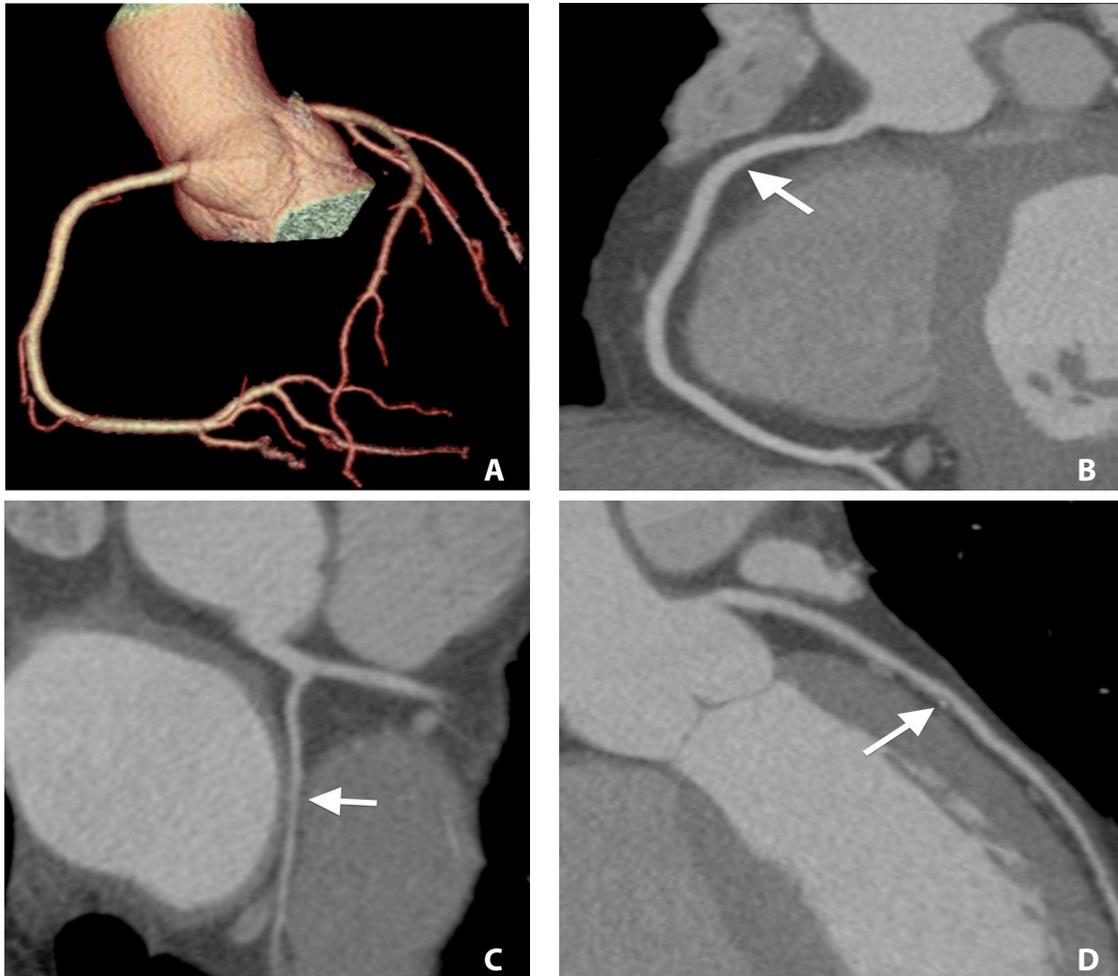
Coronary CT angiography scan. A) Volume rendering of the coronary tree. B) Curvilinear reformat of a normal right coronary artery. C) Curvilinear reformat of a normal left circumflex artery. D) Curvilinear reformat of the left anterior descending artery showing a small, non-significant mixed plaque in the mid left anterior descending artery.
